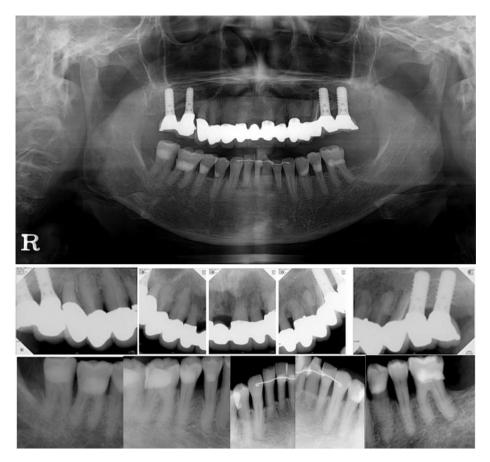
A panoramic radiograph and intraoral radiographs at the 5-year follow-up.
